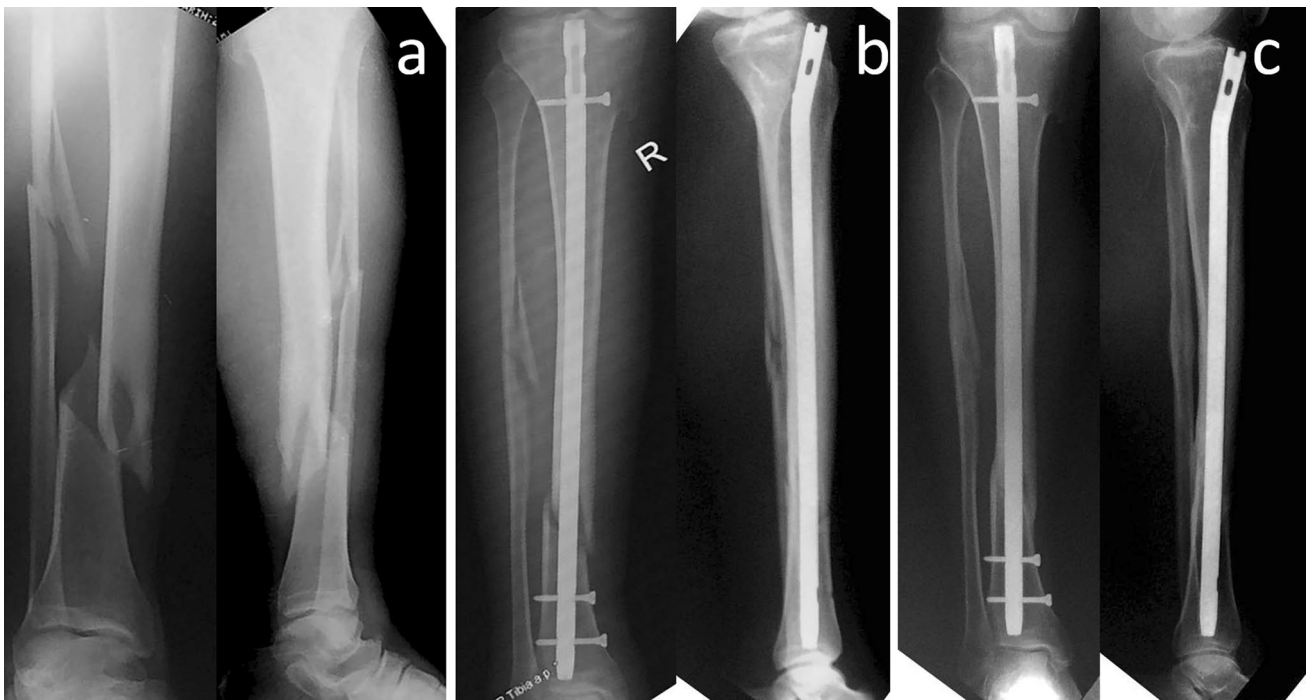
A patient treated with IMN. a Pre-operative, b early post-operative, and c final radiograph
